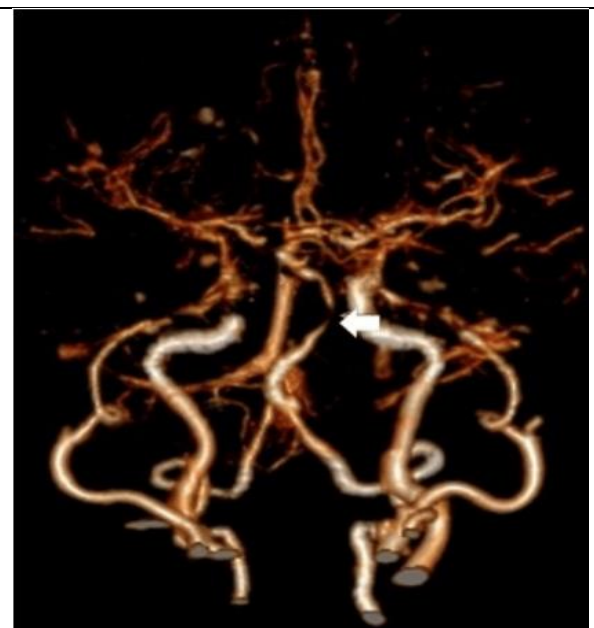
Cerebral computed tomography angiography
